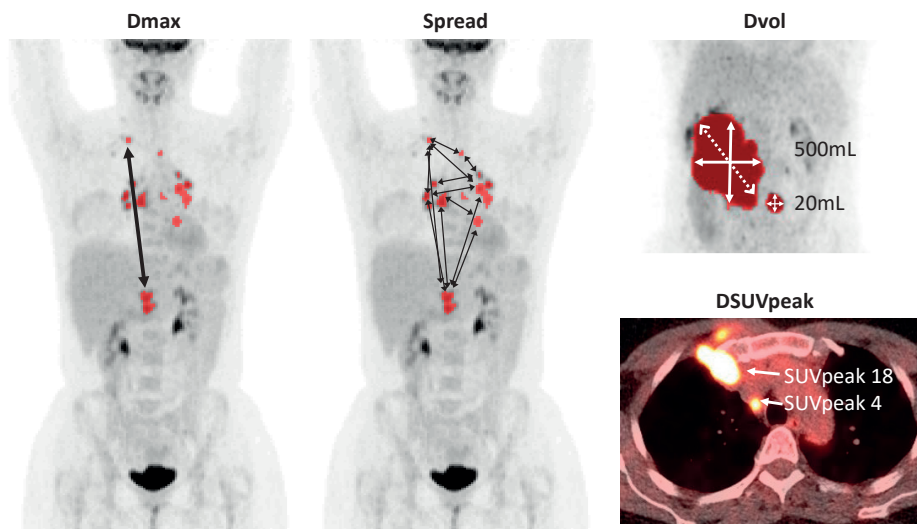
Examples of radiomics features. All definitions of radiomics features are listed in Supplemental Table 3. Dmax, maximum distance between 2 lesions; DSUVpeak, maximum difference in SUVpeak between 2 lesions; Dvol, maximum difference in volume between 2 lesions; spread, sum of the distances between all lesions.
